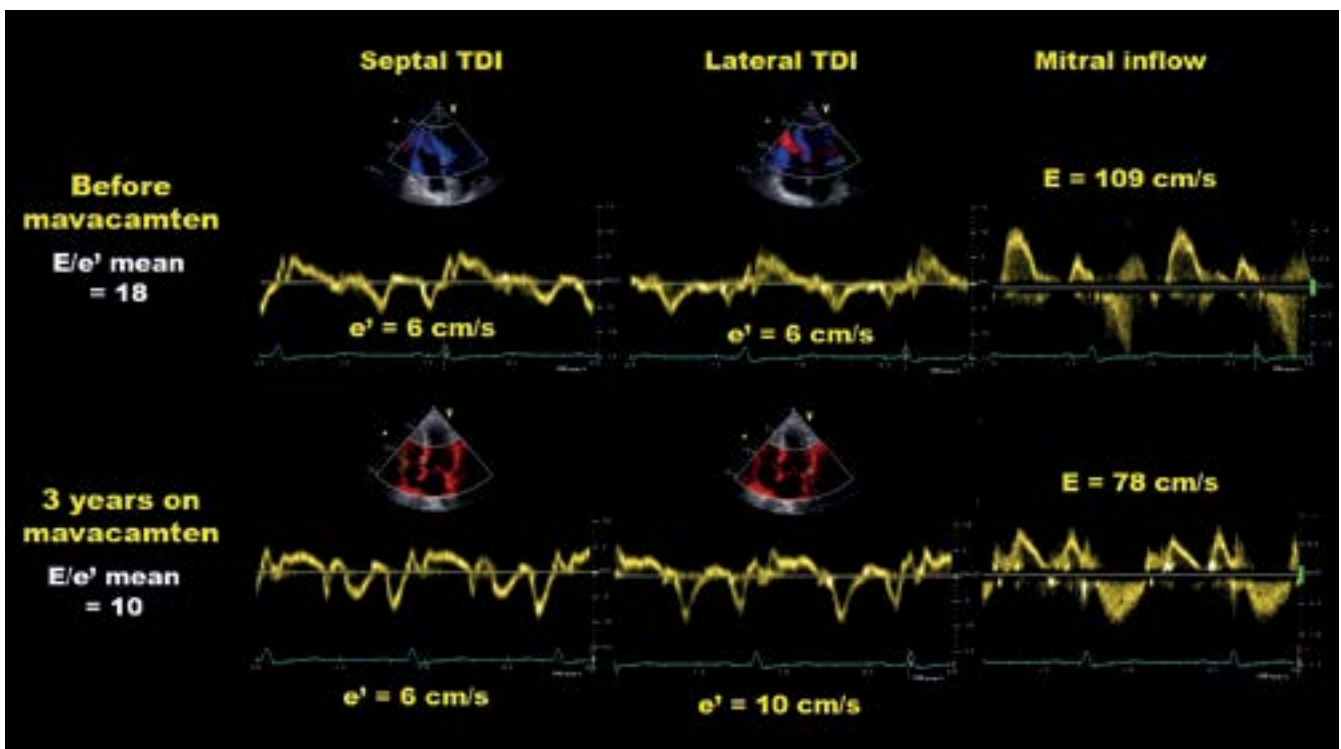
Effects of mavacamten on diastolic function in obstructive hypertrophic cardiomyopathy. Same subject as in Figure 1. E: early mitral inflow velocity; e': early diastolic mitral annular velocity; TDI: tissue Doppler imaging
